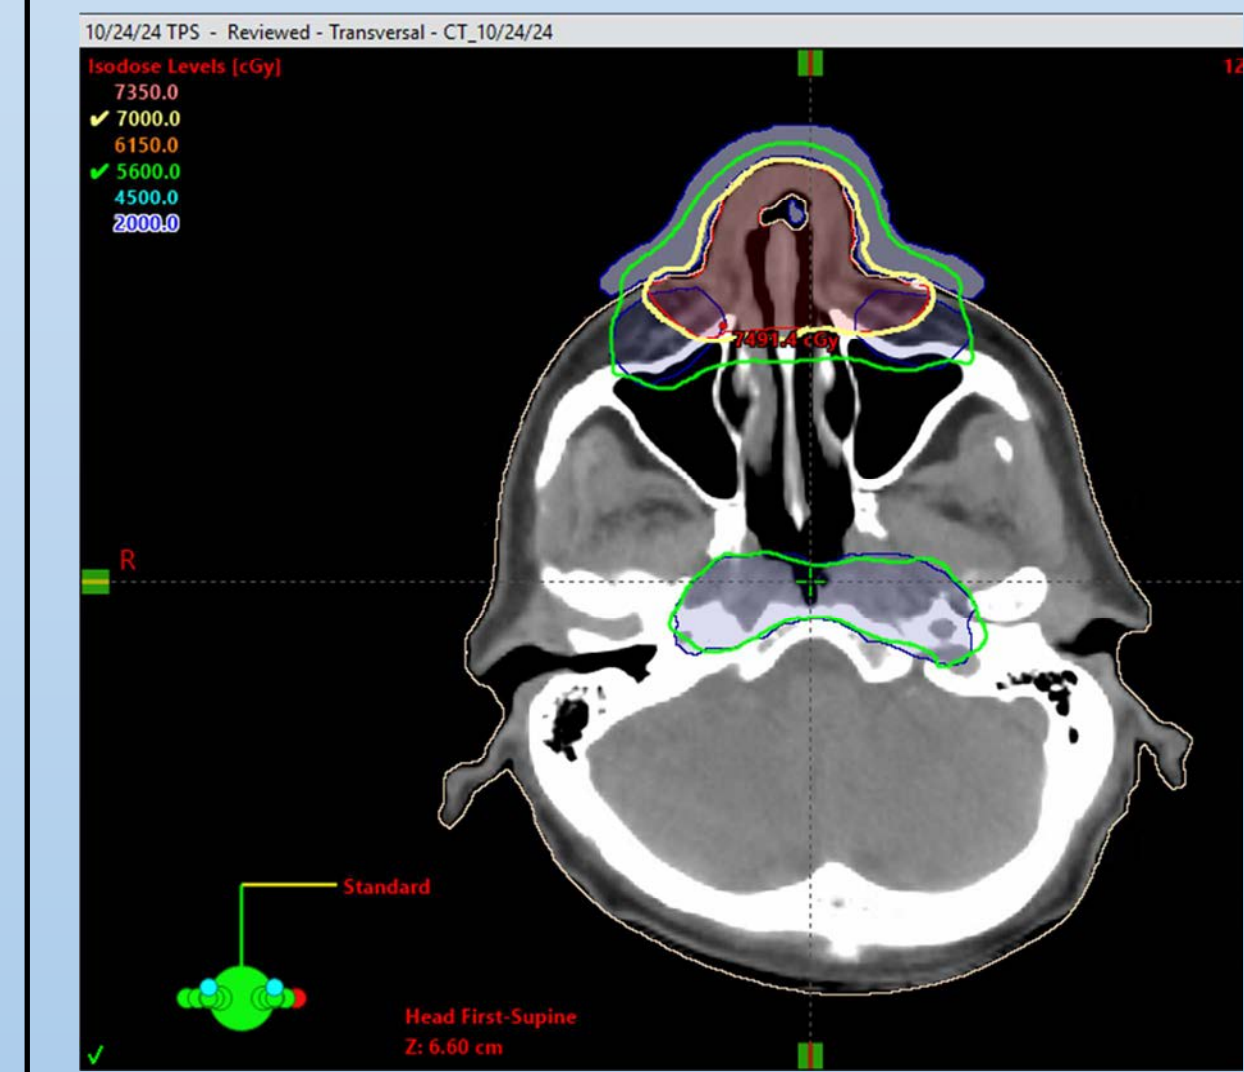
Calculated plan on CT with TPS bolus.
